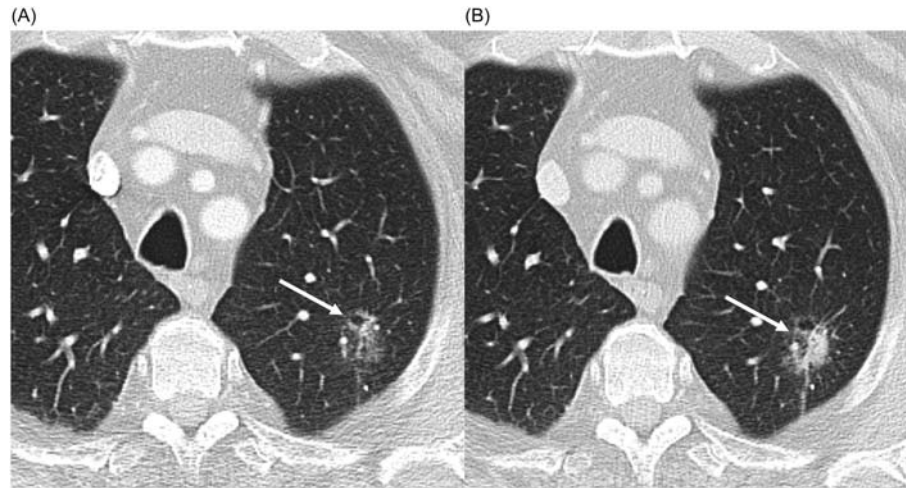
Low-dose CT scans of the lung in a participant of the German “Lung Cancer Screening and Intervention” study (LUSI), 6 months apart. The initial scan (A) shows a ground-glass opacification (*arrow*) that at follow-up (B) has increased in size and density, and would now be termed “part-solid.” Subsequent video-assisted thoracoscopy (VATS) with biopsy revealed lepidic adenocarcinoma with invasive foci.
